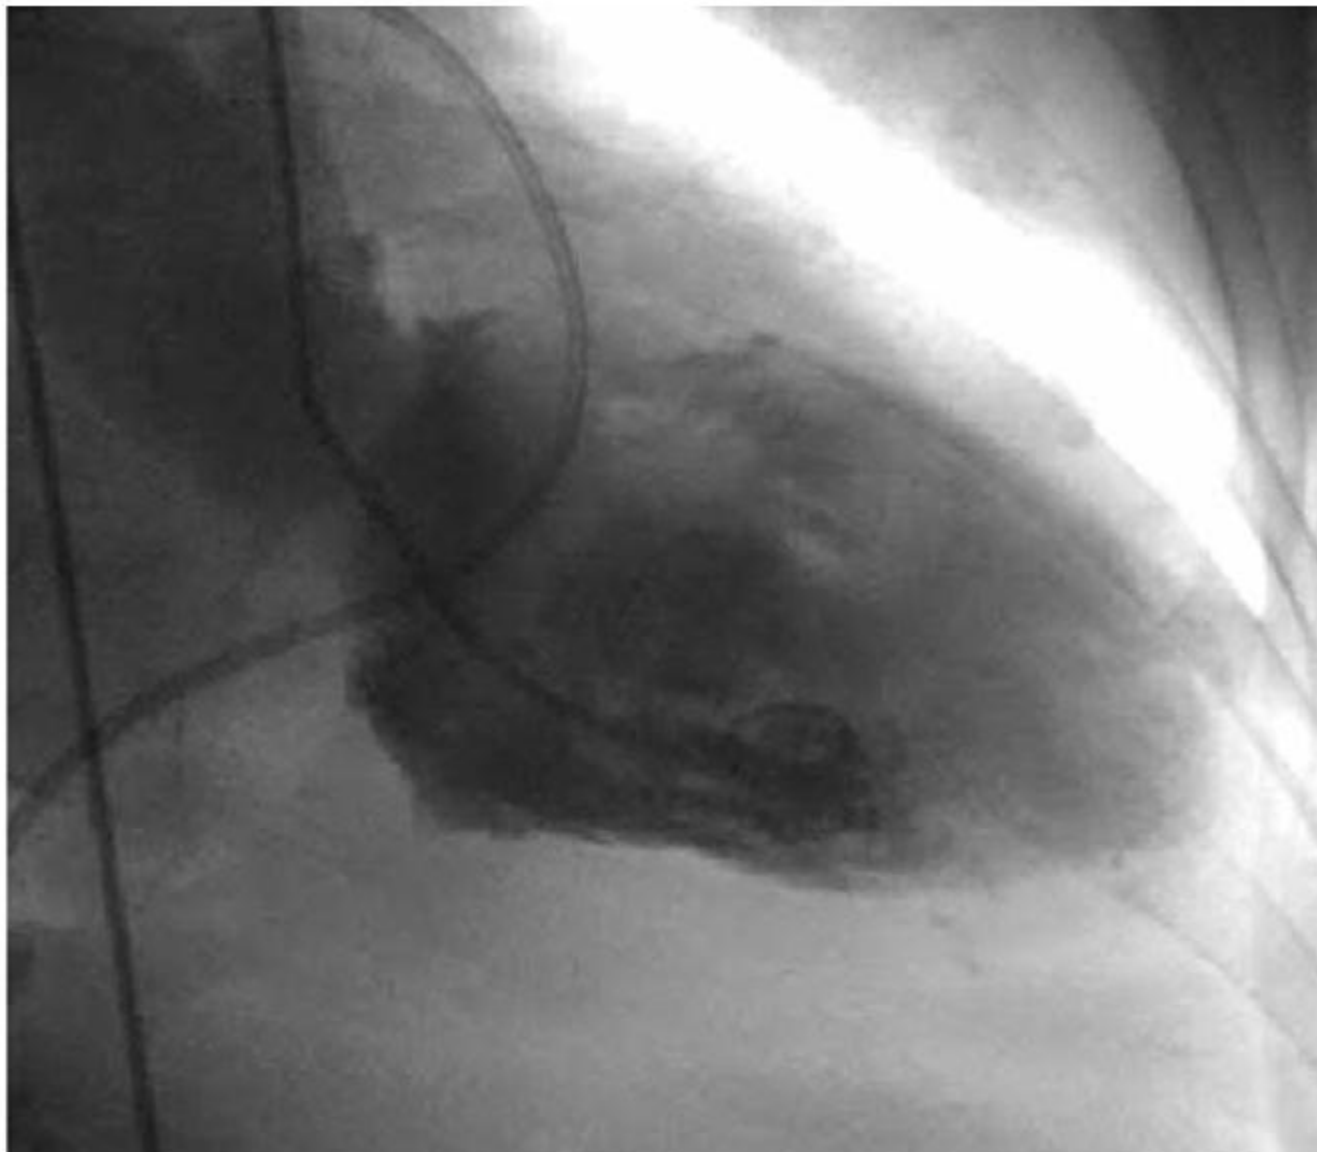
Mitral and tricuspid regurgitation. End-diastolic (A) and end-systolic (B) frames from a left ventriculogram performed in the 30° RAO projection in a patient with normal coronaries and presumptive AIDS cardiomyopathy, showing enlarged end-diastolic and end-systolic volumes, reduced ejection fraction of 38%, and 2+ mitral regurgitation. Note dye to the enlarged left atrial volume; the contrast density method underestimated the severity of regurgitation, shown to be moderately severe by a regurgitant fraction of 36% and transesophageal echo. End-systolic (C) frame from a right ventriculogram in the same patient performed in the 30° RAO projection showing 2+ tricuspid regurgitation (LA, left atrium; RA, right atrium; PA, pulmonary artery).
